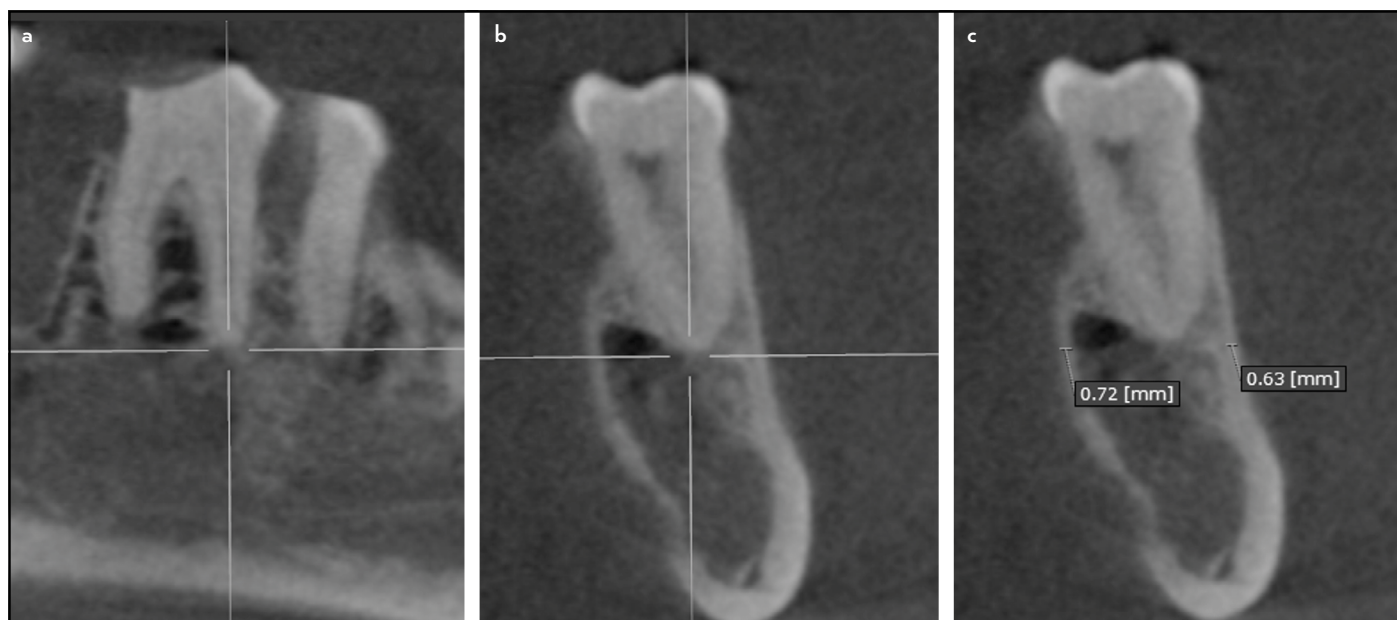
CBCT images representing cortical measures to avoid bias regarding its influence on PL detection. Images were reoriented according to the long-axis of the tooth (a), and measures were done immediately below the dental socket plane (b), in both buccal and lingual cortical plates (c)
